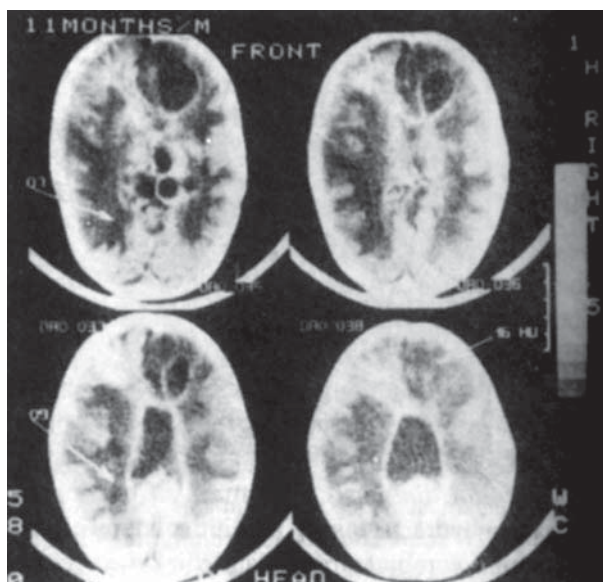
Computed tomography scan showing multiple brain abscesses.
